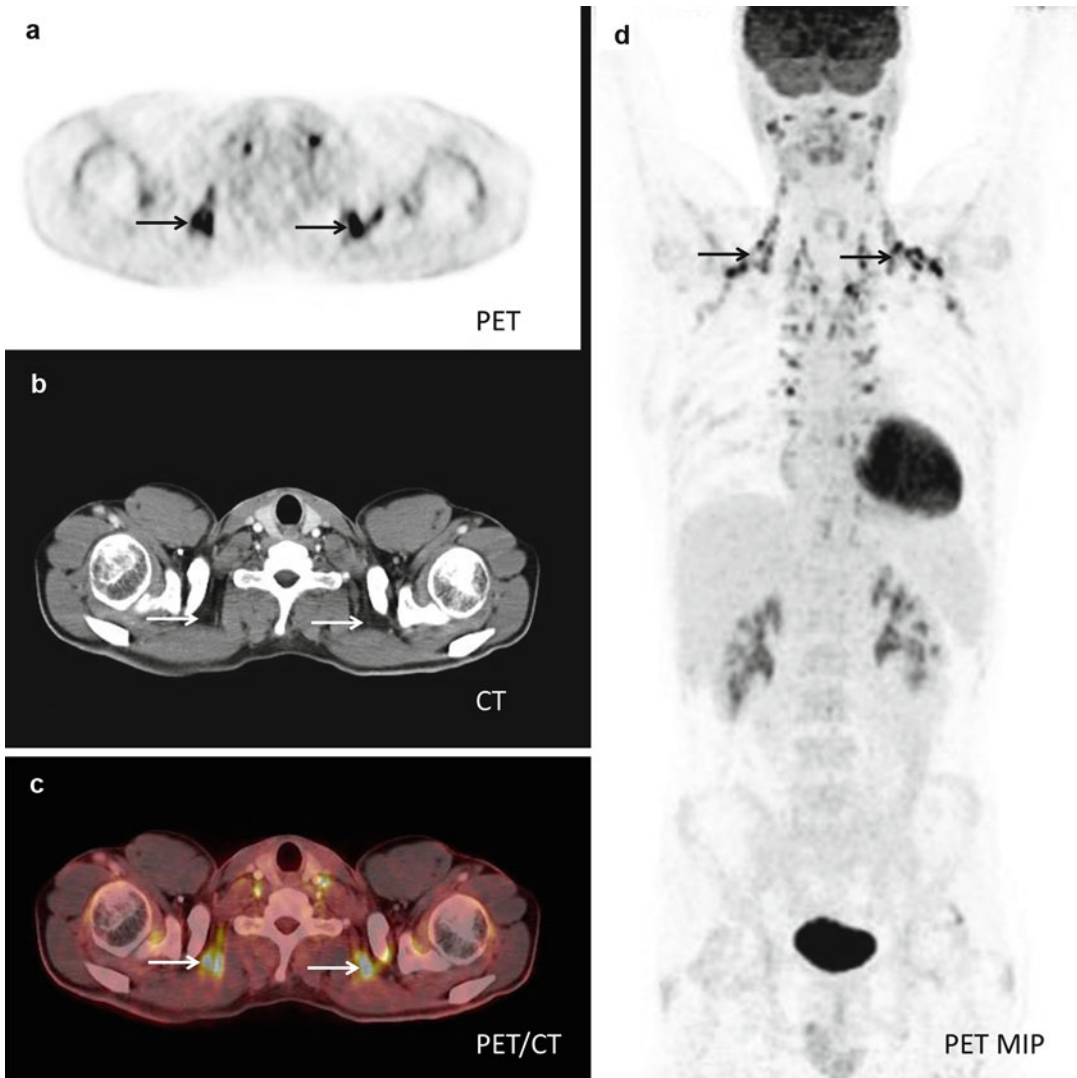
PET-CT showing physiological FDG-uptake in brown fat: (a) PET shows intense FDG-uptake especially in the supraclavicular region (*arrows*). (b) CT shows high resolution anatomical images of the same region. (c) Fused
